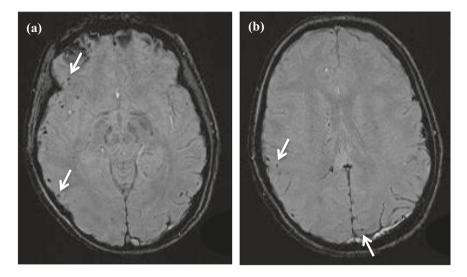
A 46 year old woman sustained head trauma in a road traffic accident. On presentation she was comatose (GCS 7). A CT scan showed a shallow subdural haematoma. Her GCS remained low and an MRI was performed for further evaluation. These MRI susceptibility weighted images (a sequence which is sensitive to haemorrhage) show numerous small foci of low signal (black dots, several of which are labeled with arrows) at the grey-white matter junction, characteristic of diffuse axonal injury
